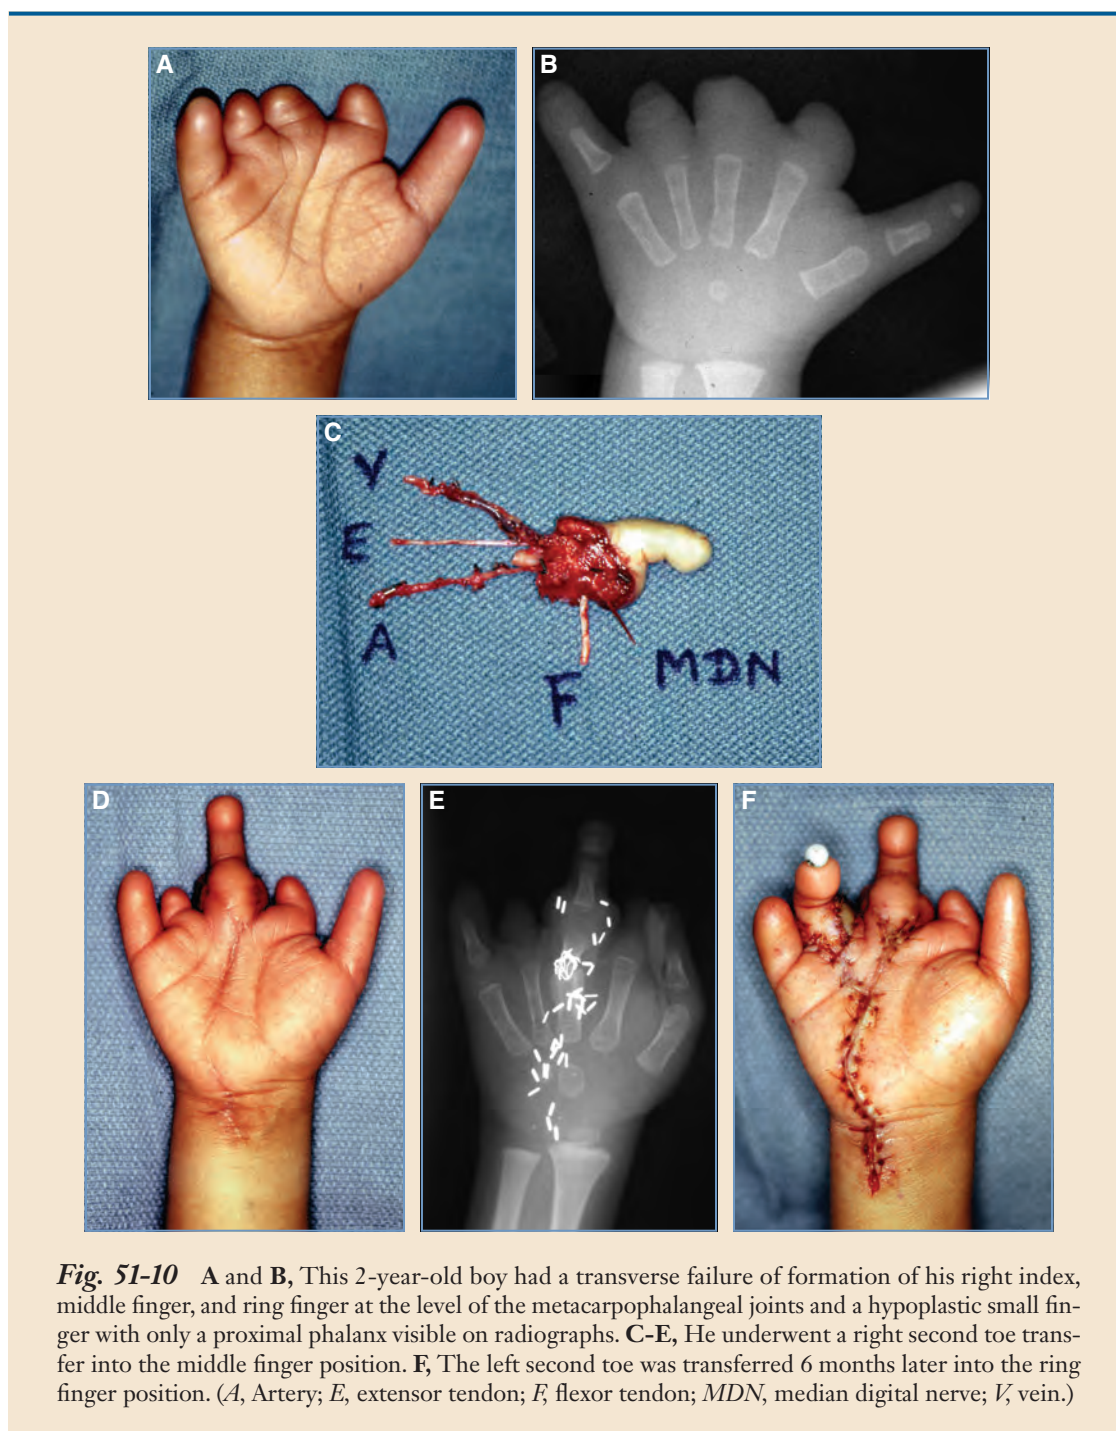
A and B, This 2-year-old boy had a transverse failure of formation of his right index, middle finger, and ring finger at the level of the metacarpophalangeal joints and a hypoplastic small finger with only a proximal phalanx visible on radiographs. C-E, He underwent a right second toe transfer into the middle finger position. F, The left second toe was transferred 6 months later into the ring finger position. (A, Artery; E, extensor tendon; F, flexor tendon; MDN, median digital nerve; V, vein.)
